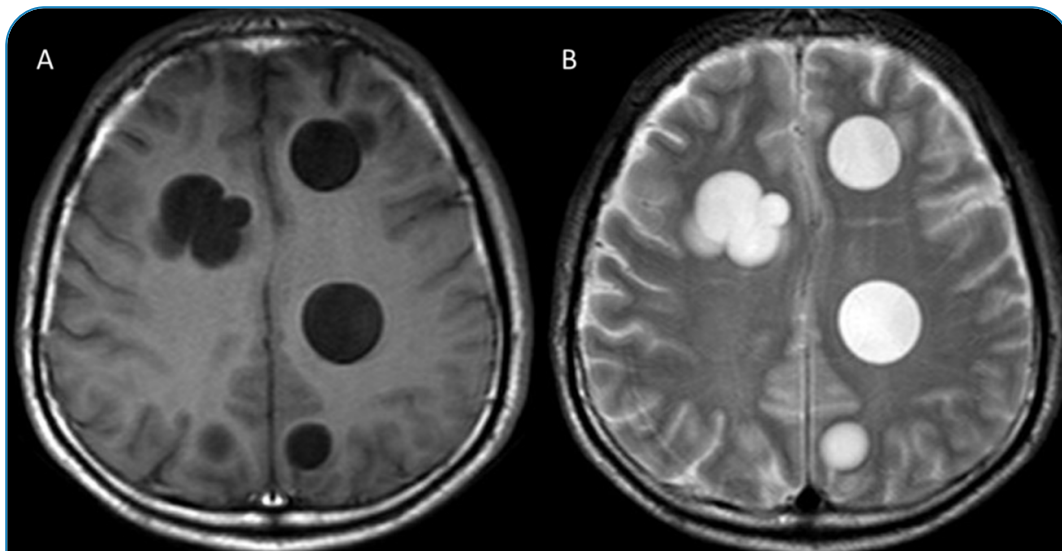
Magnetic resonance imaging of the patient's brain reveals multiple round, multivesicular T1-hypointense (A) and T2-hyperintense (B) lesions in both cerebral hemispheres.
